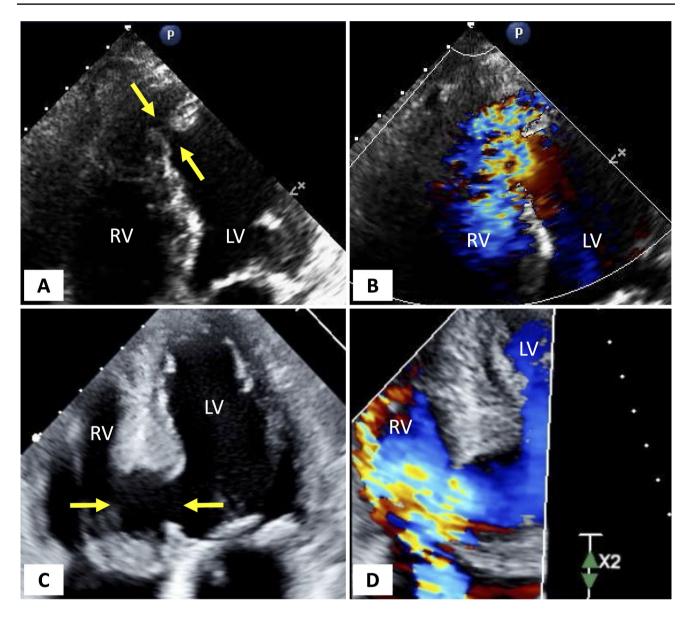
A, B Transthoracic echocardiography demonstrating ventricular septal rupture with a simple defect of the apical septum (*yellow arrows*) after a delayed presentation of an LAD ST-segment elevation myocardial infarction. Note the turbulent flow in the RV, a result of high velocity left-to-right shunting. C, D Transthoracic echocardiography demonstrating ventricular septal rupture with a very large
